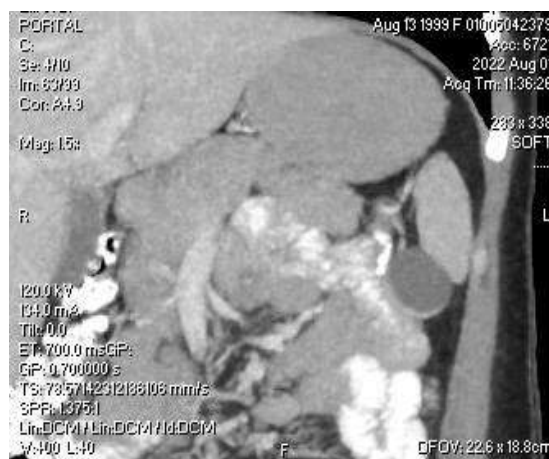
Abdominal CT, Accessory spleen cyst, branch of the splenic artery.
